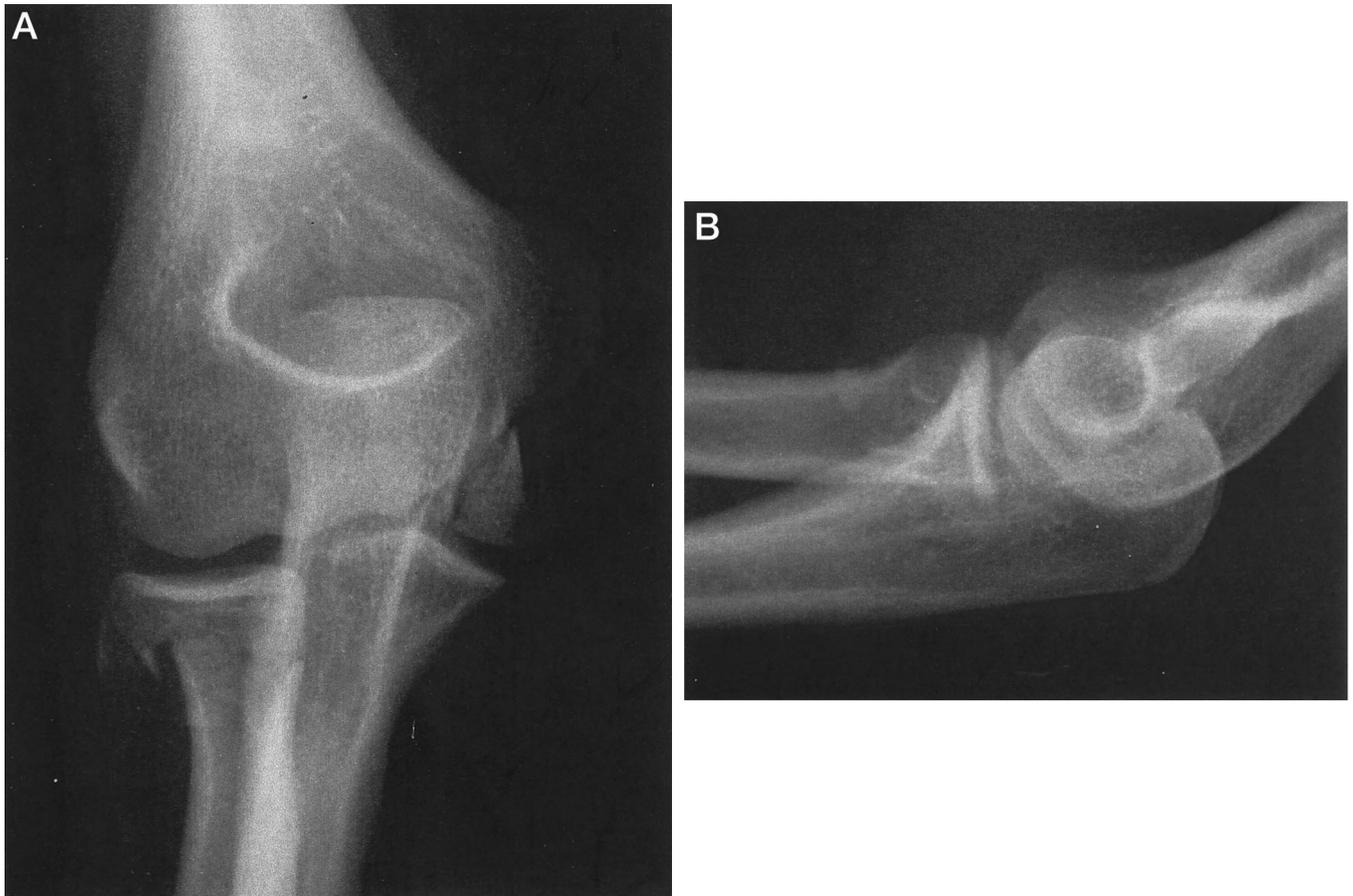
Initial anteroposterior (A) and lateral (B) radiographs of the elbow demonstrating the fractures of the trochlea and the radial neck.
